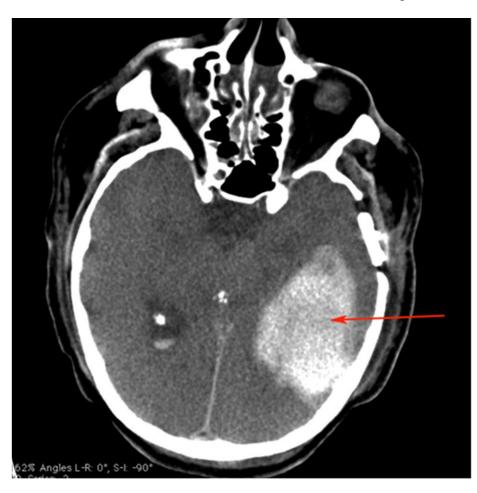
Case AF. 91 y.o, female with Intracerebral Hemorrhage (arrow) in right MCA affecting frontal and parietal lobe producing the stroke. CT.
